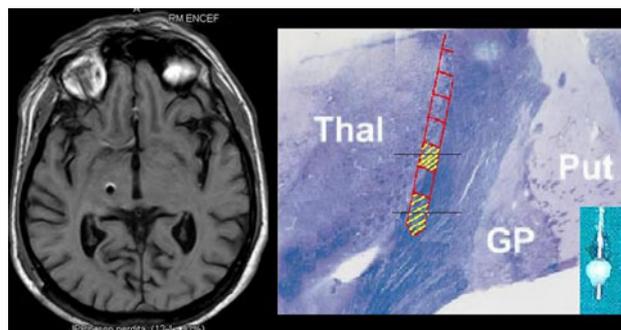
Postop MRI (*left panel*) showing the electrode placement close to the IC and adjacent to the sensory thalamus in a patient with post-stroke pain referred in the lower limb. In the *right panel* graphic representation of the coronal section at the target showing the boundaries of the thalamus and the IC fibers. In the *lower right corner* of the image are represented the electrode and the estimated electric field, which in our case involved the thalamic sensory nucleus and IC fibers
